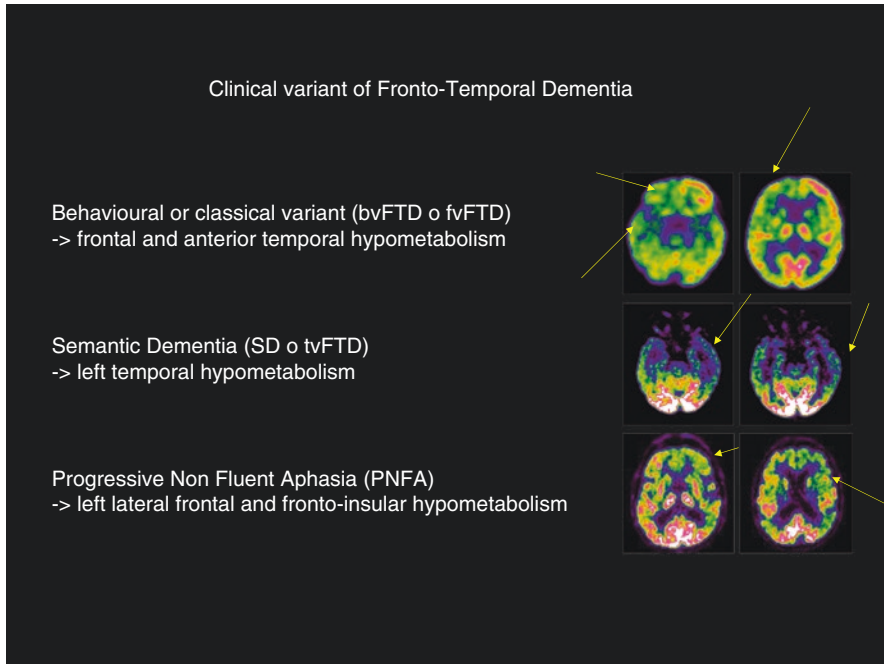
FDG-PET patterns of hypometabolism in clinical variant of frontotemporal dementia
